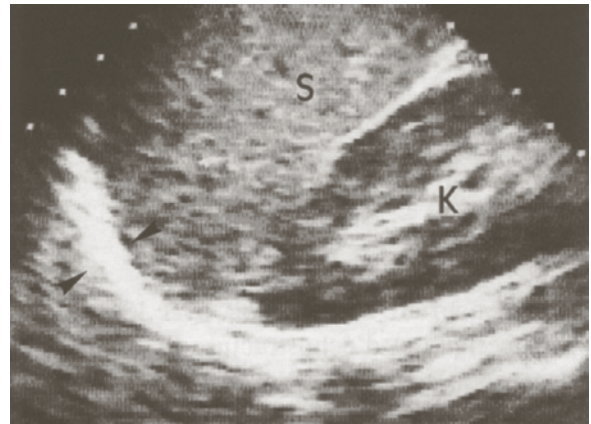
Spleen and left kidney in a longitudinal scan. Note the left hemidiaphragm (*arrows*) just over the spleen (*S*). The kidney (*K*) is located in the splenic concavity. As in Fig. 4.8, the interface between spleen and kidney is fully distinct from the cupola. Note that the structures located above the cupola cannot be interpreted; they can be ghost mirror echoes as well as alveolar consolidation. This route is not adequate for lung or pleural ultrasound
